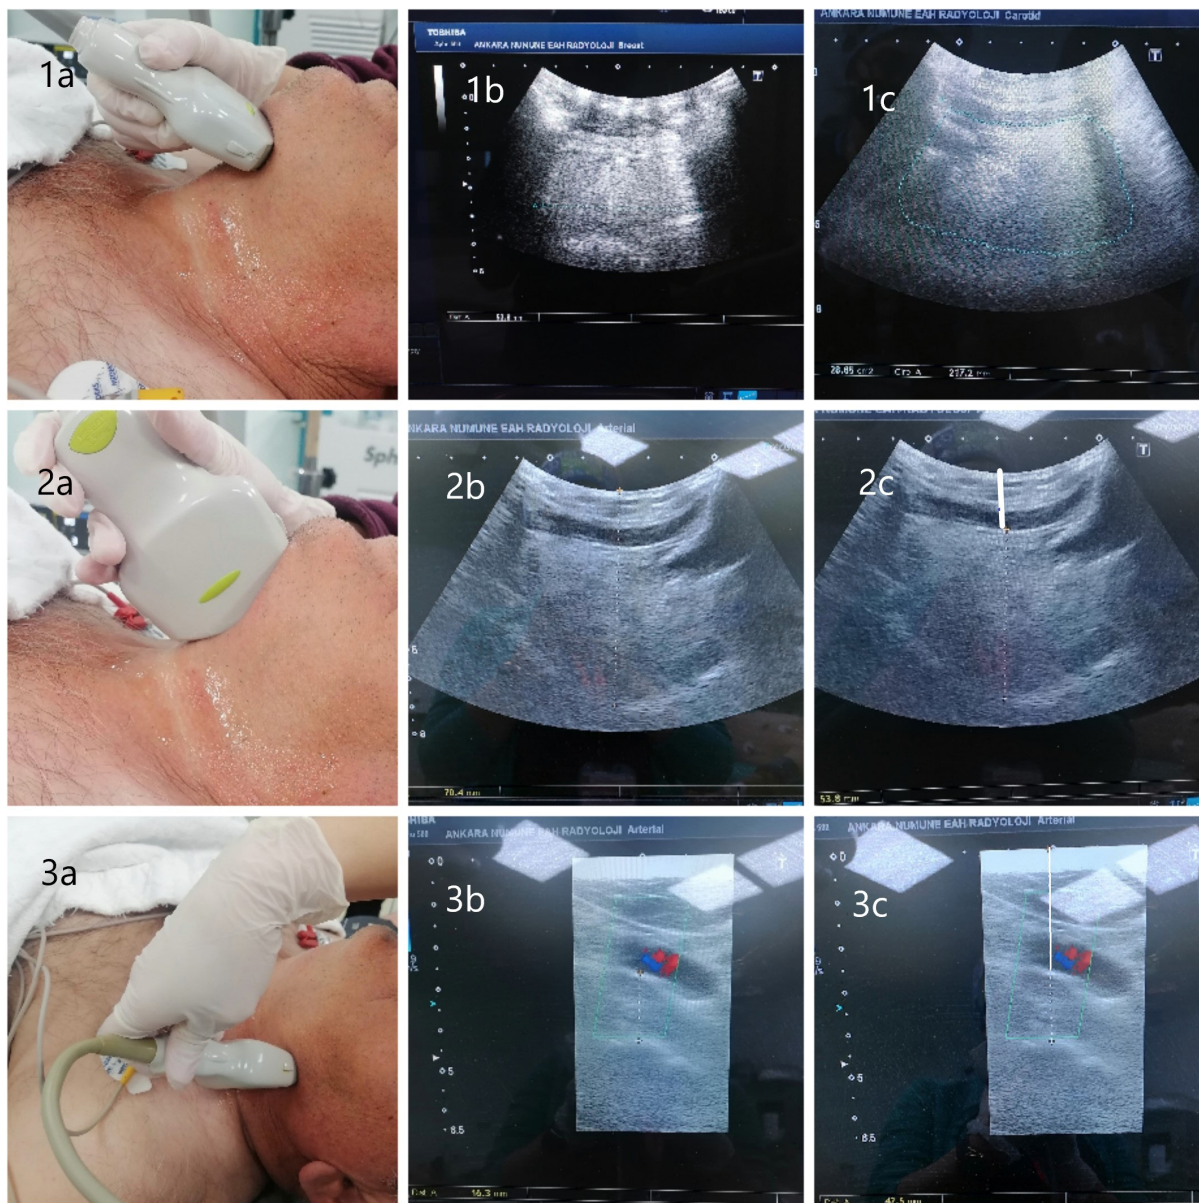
1a, Positioning of the ultrasound probe and sonographic anatomy of the suprahyoid airway in the transverse scan. 1b, Blue dotted line: width of the tongue. 1c, Blue dotted area: cross-sectional area of the tongue. 2a, Positioning of the ultrasound probe and sonographic anatomy of the suprahyoid airway in the midsagittal scan. 2b, White dotted line: tongue thickness. 2c, White line: submental region thickness. 3a, The ultrasound transducer was oriented transversely in the lateral neck. 3b, White dotted line: ultrasound image of the lateral pharyngeal wall. The internal carotid artery is shown by Doppler imaging. 3c, White line: parapharyngeal region thickness
